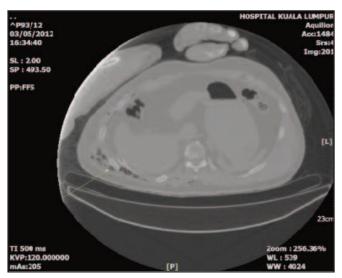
Axial view of plain post mortem CT scan of same patient in Figure 2 (A) in bone window showing associated lower rib fracture (arrow). Demonstration of bony fracture was an advantage of post mortem CT as compared to conventional autopsy.
